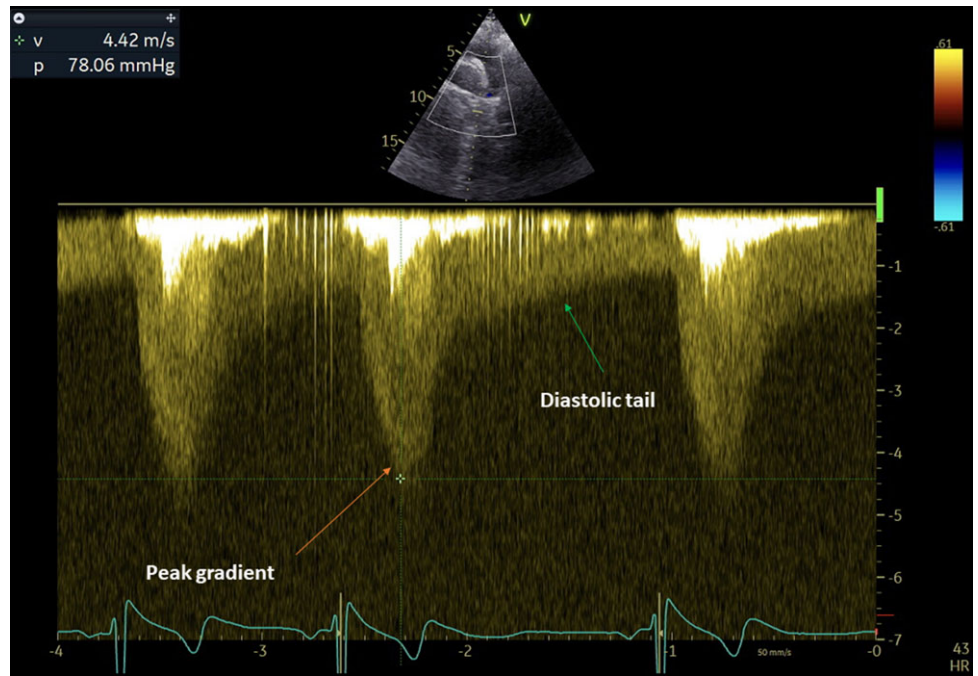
Doppler profile on the aortic isthmus: peak gradient of 78 mmHg (red arrow) with diastolic tail (green arrow).
